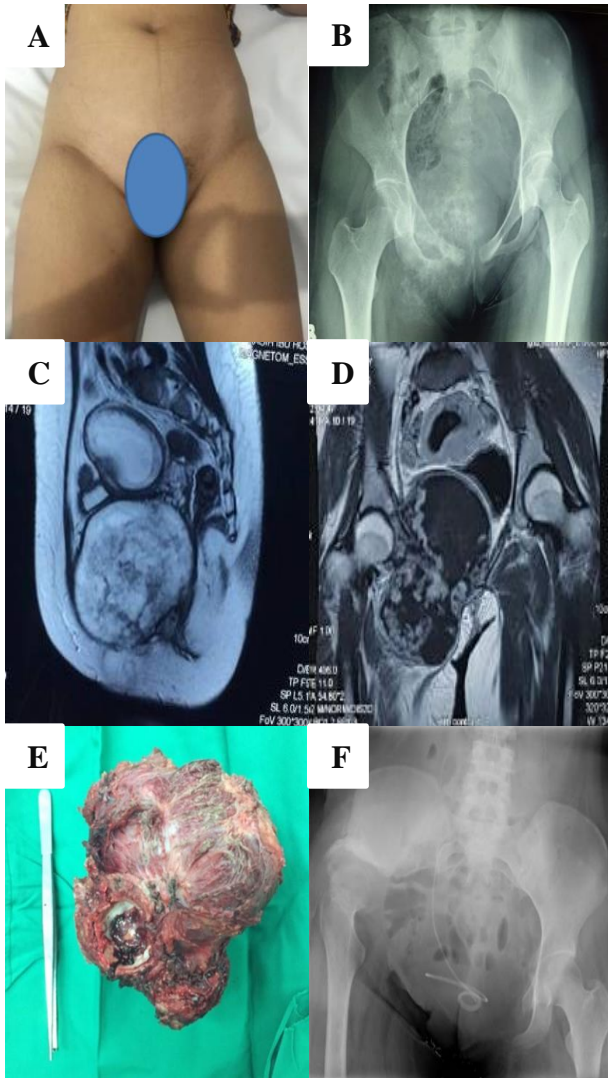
A, B) Mass on the groin to medial part of proximal thigh and after wide excision; C) Clinical after NFVG; D) Pelvic X-ray post operatively.
